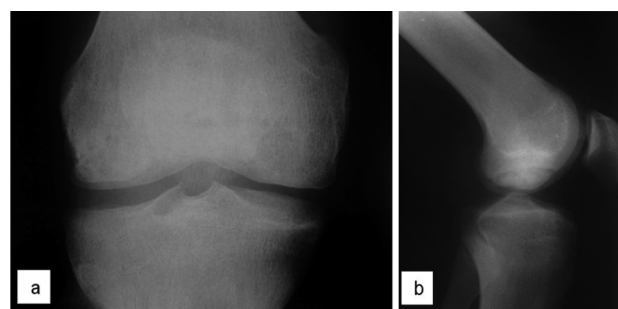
Antero-posterior (a) and lateral (b) plain radiographs of the right knee one year after fixation of osteochondral fragments demonstrating good results of healing process in both femoral condyles.
